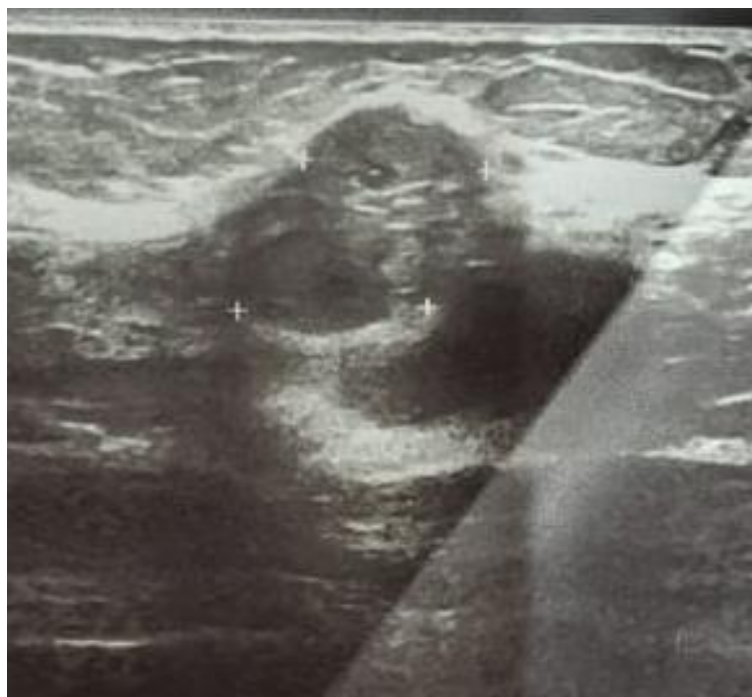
Ultrasound appearance of the lesion
